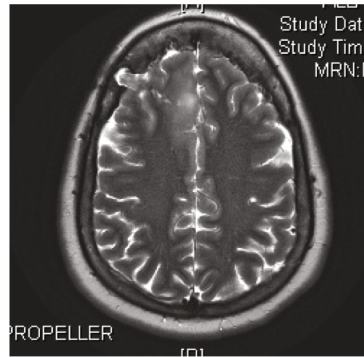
MRI showing ill defined gyral expansion of the right anterior parasagittal frontal lobe
